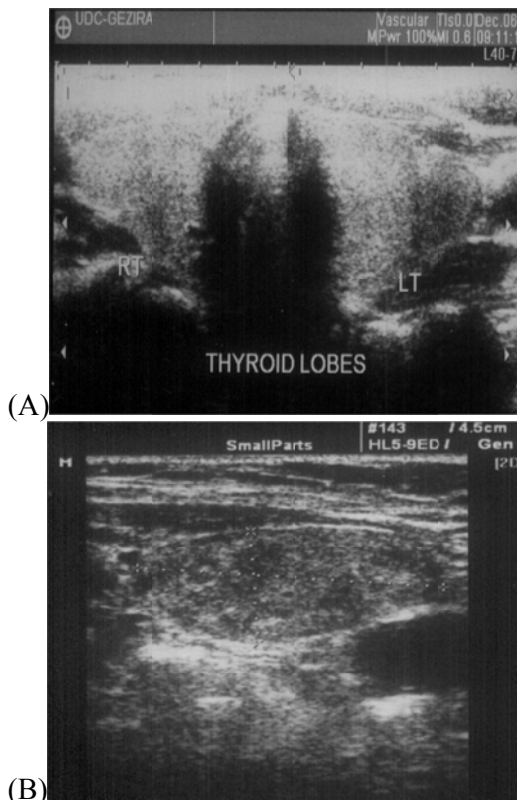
Ultrasound showing (A) a normal thyroid gland in its normal anatomic position and (B) soft tissue nodule seen cranial to normal thyroid gland with similar echotexture. This is the same patient seen in (Fig. 2).
